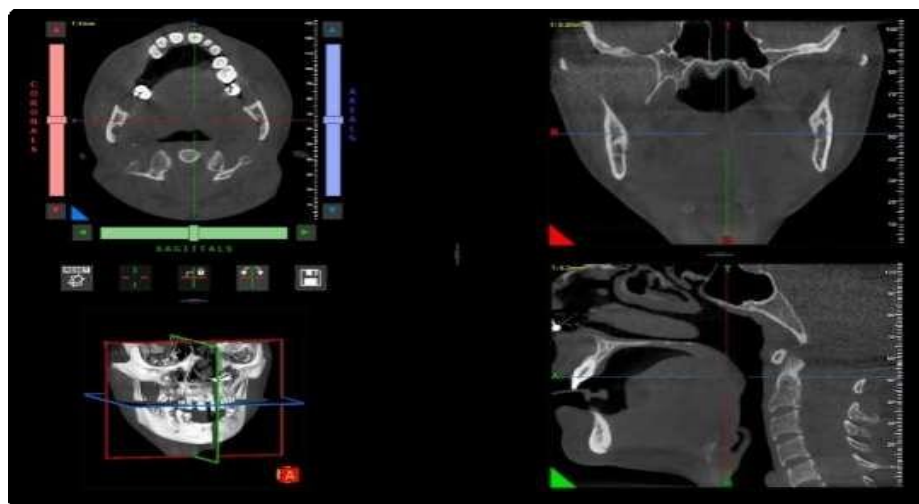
Sagittal section of CBCT showing nutrient canal in mandibular anterior region
